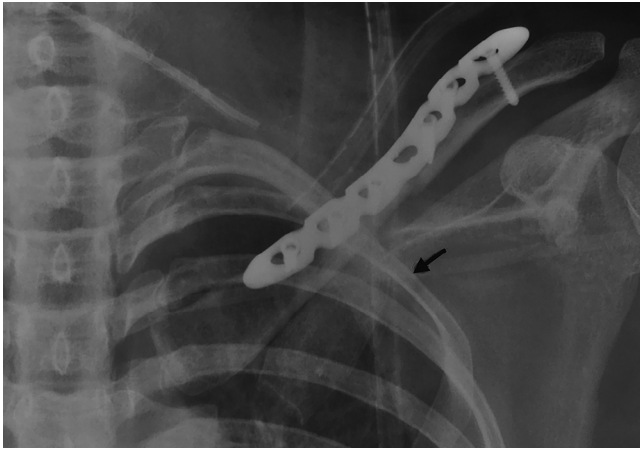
Postoperative x-ray of neck showing the second rib deformity caused by the lump's perennial compression.
